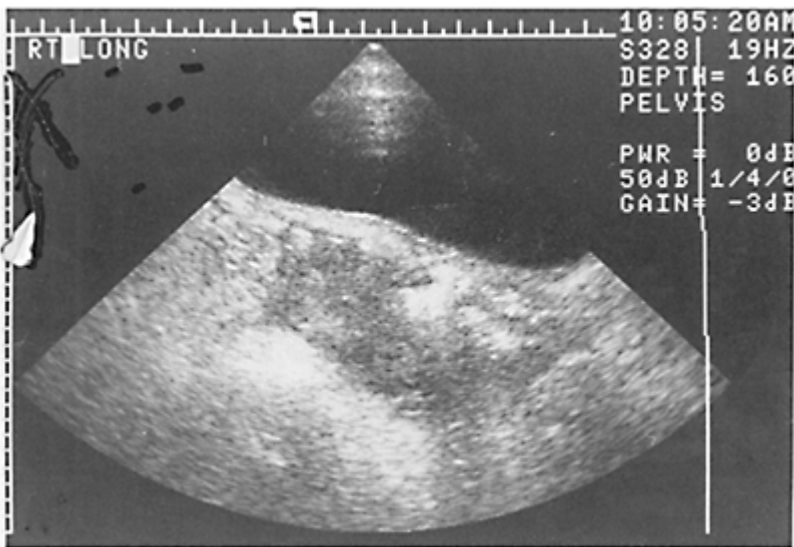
Ultrasonographic demonstration of a postoperative pelvic abscess which has the potential for fine needle aspiration (Courtesy of Susanne Granger, MD)
